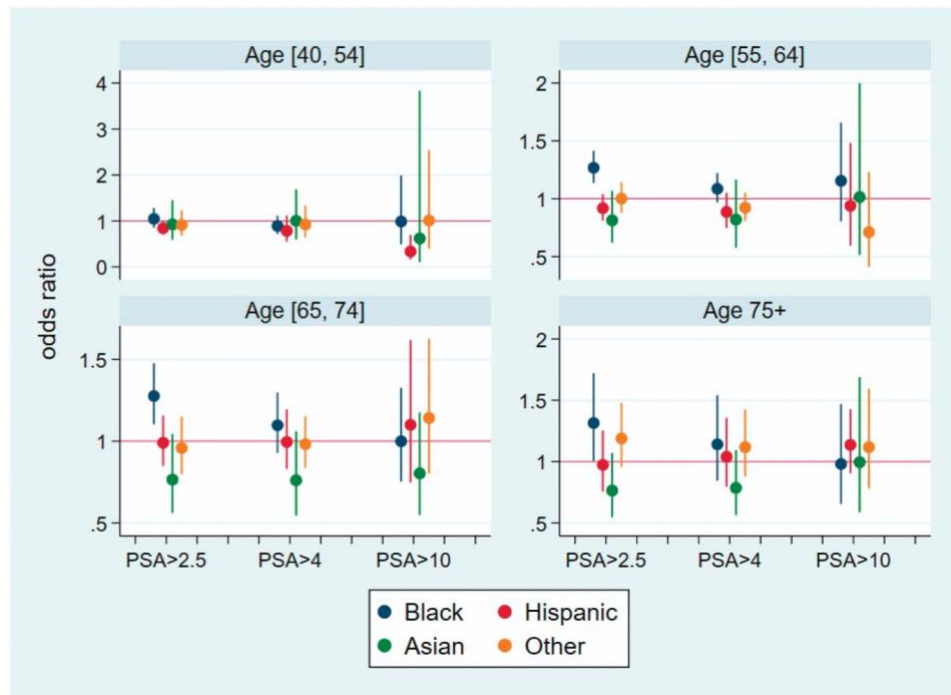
2: Odds ratio of subsequent prostate MRI or biopsy by age and PSA score
